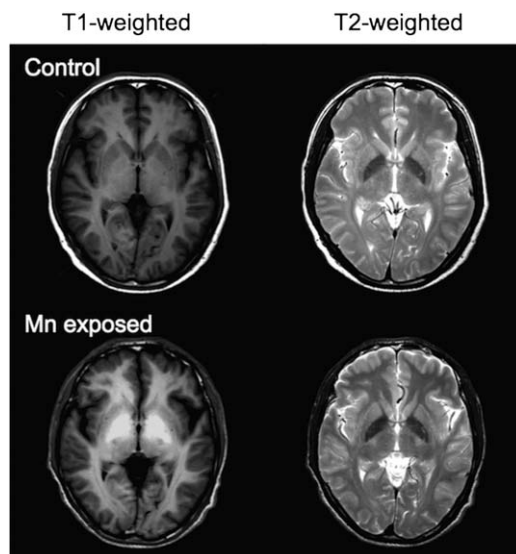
T_1 -weighted (left) and T_2 -weighted (right) MRI images of the same brain slice in an unexposed control subject (top row) and a Mn-exposed metal worker (bottom row). The bright signal in the globus pallidus and surrounding areas in the T_1 -weighted image of the exposed subject reflects increased Mn concentration. The dark signal intensity of the globus pallidus in the T_2 -weighted images reflects the effects of a large iron content in the globus pallidus (seen in both subjects) as well as the increased Mn deposition (a combined effect in the exposed subject).
